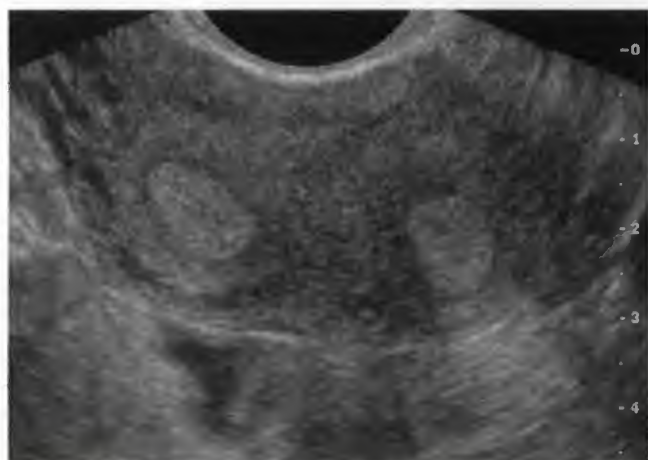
Ultrasound images of the uterus taken in the mid-sagittal plane showing the five primary patterns of endometrial development (M, A to D). For orientation, the cervix is located just out of the image to the right of the image and the fundus is seen to the left of the image. Evidence of active menstrual bleeding is observed within the uterine lumen (M). A thin, simple hyperechoic single stripe seen immediately following menstruation (A). Early follicular phase triple-line pattern indicative of increasing estradiol levels (B). Late follicular phase pronounced triple-line pattern with distinct separation of the stratum basalis and stratum functionalis observed with the high estradiol levels associated with the periovulatory period (C). Postovulation heterogenous, fully secretory endometrial pattern indicative of luteinization and exposure of the endometrial tissues to progesterone (D). Arrows identify the stratum basalis-myometrium interface. (Reprinted with permission from Baerwald AR, Pierson RA: Endometrial development in association with ovarian follicular waves during the menstrual cycle. *Ultrasound Obstet Gynecol* 24:453, 2004.)
